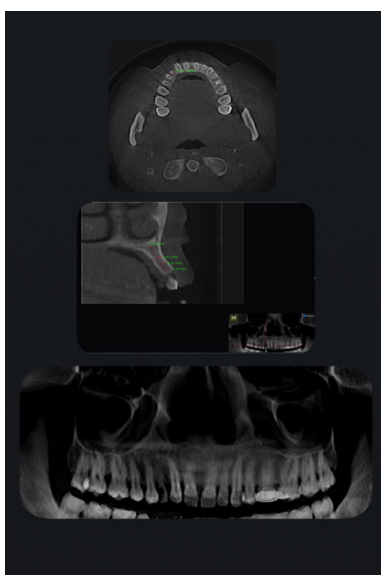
CBCT images with bone dimensions
